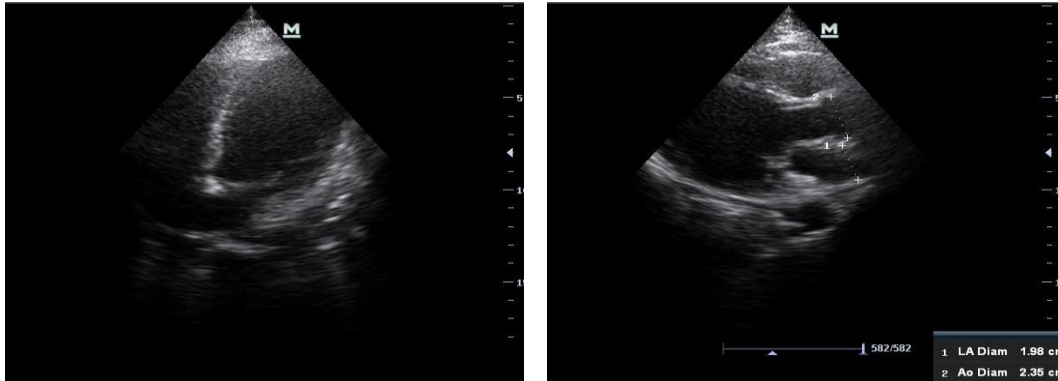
Echocardiography showing dilated and dyskinetic mid and distal left ventricular segment.
